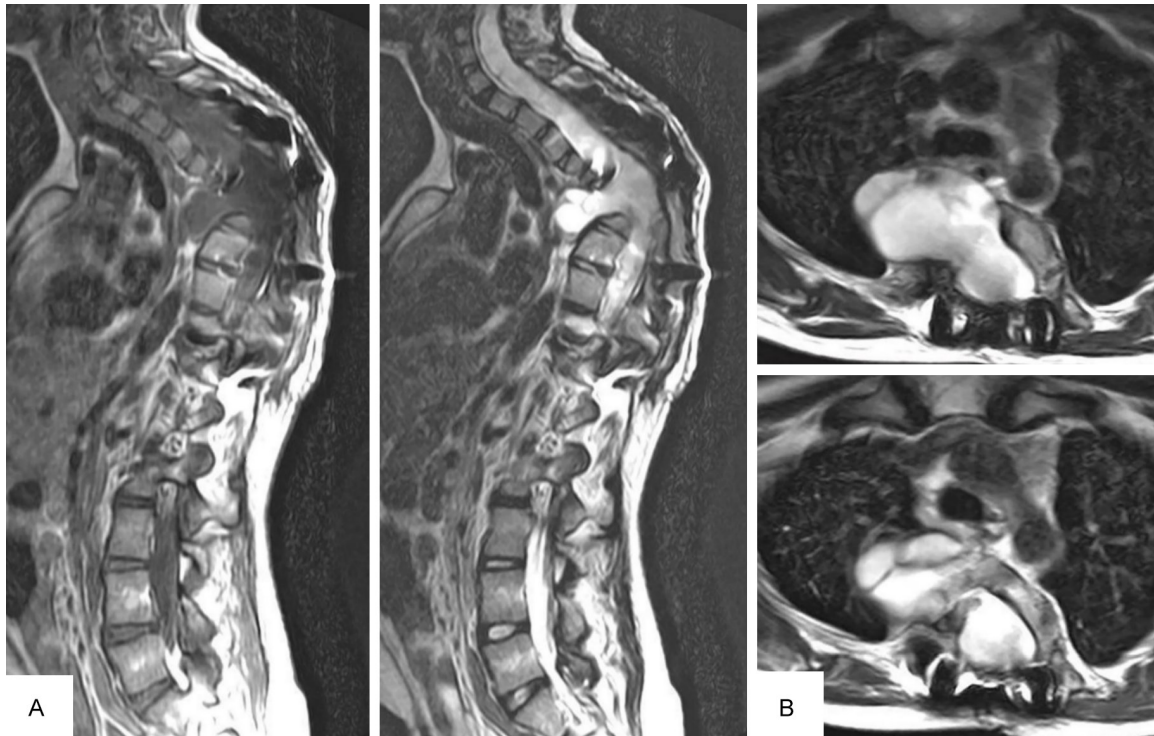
MRI revealed a bag-like long T1 and long T2 signal shadow in front of the T7-T8 vertebral body, with a range of approximately 5.76×4.05 cm (A). Compared with the preoperative signal, the signal inside the bulging meninges was uniform, and no clear spinal cord signal shadow was found (A/B). The lesion locally communicated with the adjacent spinal canal, and the spinal canal was dilated at the level of the T4-T8 vertebral body (A).
